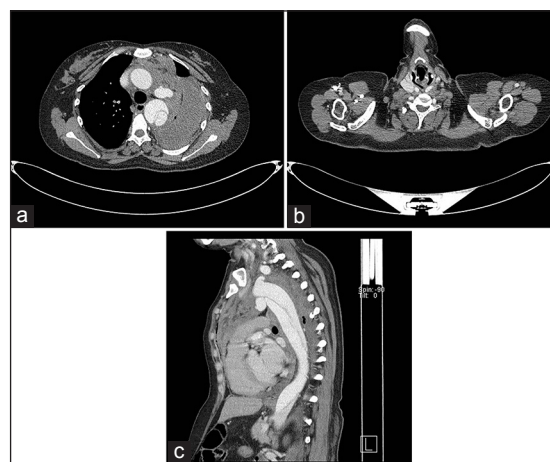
Axial contrast CT. Thorax study showed dissection of the arch and descending aorta extending inferiorly up to the abdominal aorta with left hemothorax and hemomediastinum and collapse of the underlying lung (a and b). Contrast opacified outpouching arising from the inferior arch of the aorta and opposite to subclavian origin (c)
